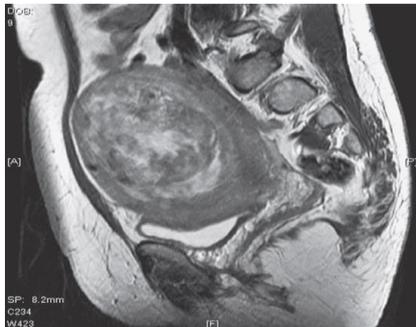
MRI of the abdomen and pelvis
